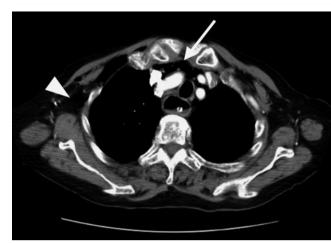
Chest computed tomography (CT) revealed subcutaneous emphysema and pneumomediastinum (arrows).
